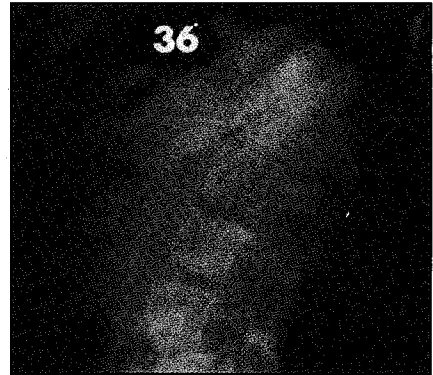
Lateral radiograph of same patient at the same time with sagittal curve of 36 degrees.
